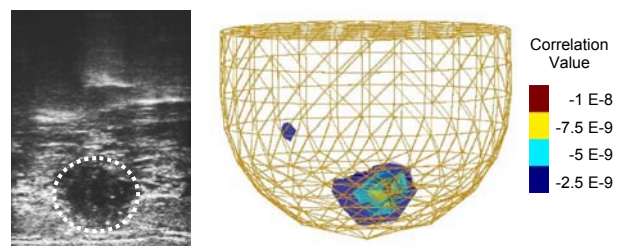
Right: 3D map of correlation values for the temporal variations of oxygenation states in the tumor bearing breast. Left: Sonogram of the same breast, approx. at same scale.
